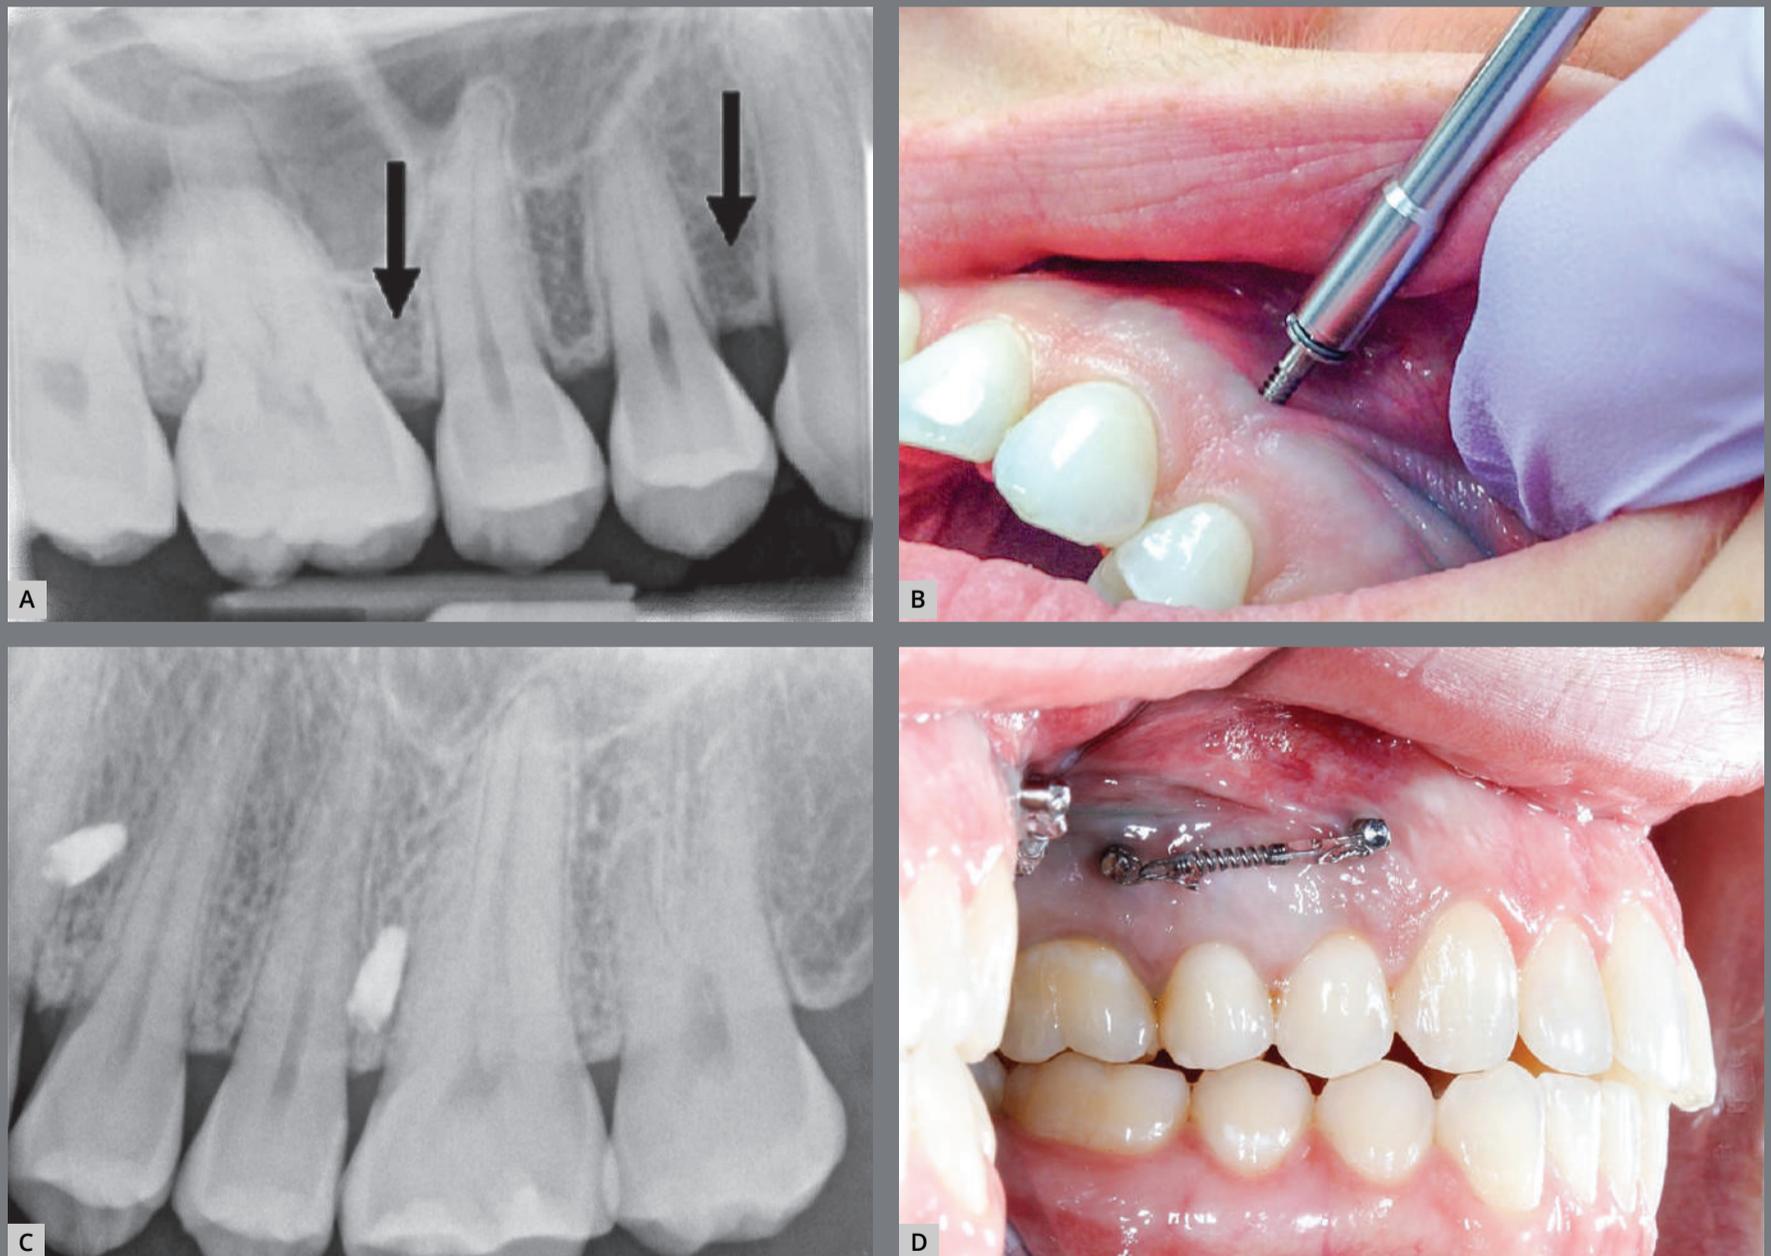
A) Periapical radiograph taken to visualize bone between the teeth (planned MSI sites indicated by black arrows), B) insertion of MSI, C) periapical radiograph taken after MSI placement, D) pair of MSIs after immediate loading with a force of 100 g.
